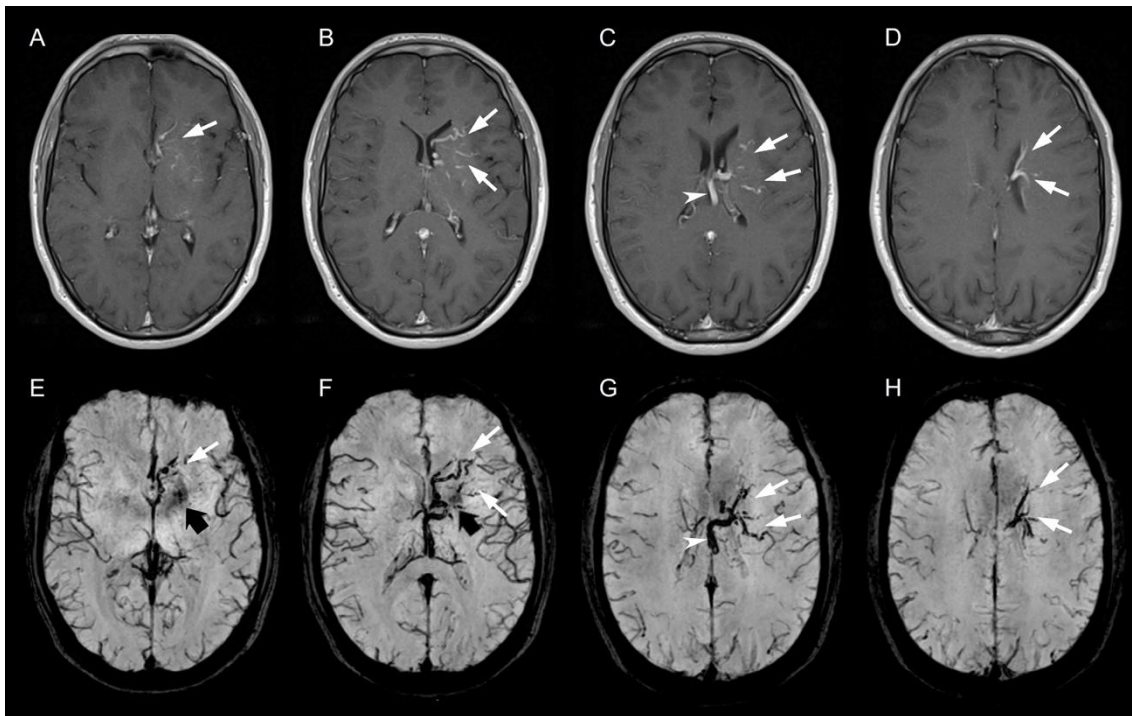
Brain MRI including contrast-enhanced axial T1WI (A-D) images show the venous radicles (*white arrows*) and the venous collector (*white arrowhead*) of the developmental venous anomaly (DVA) previously presented on Fig. 1.3.3. The lesion is also well-defined in axial SWI magnitude images (E-H) (*white arrows* and *white arrowheads*). Note the small foci of susceptibility effect in the left globus pallidus (*thick black arrows*), corresponding to the area of calcification also demonstrated in the axial unenhanced CT images of Fig. 1.3.3.
